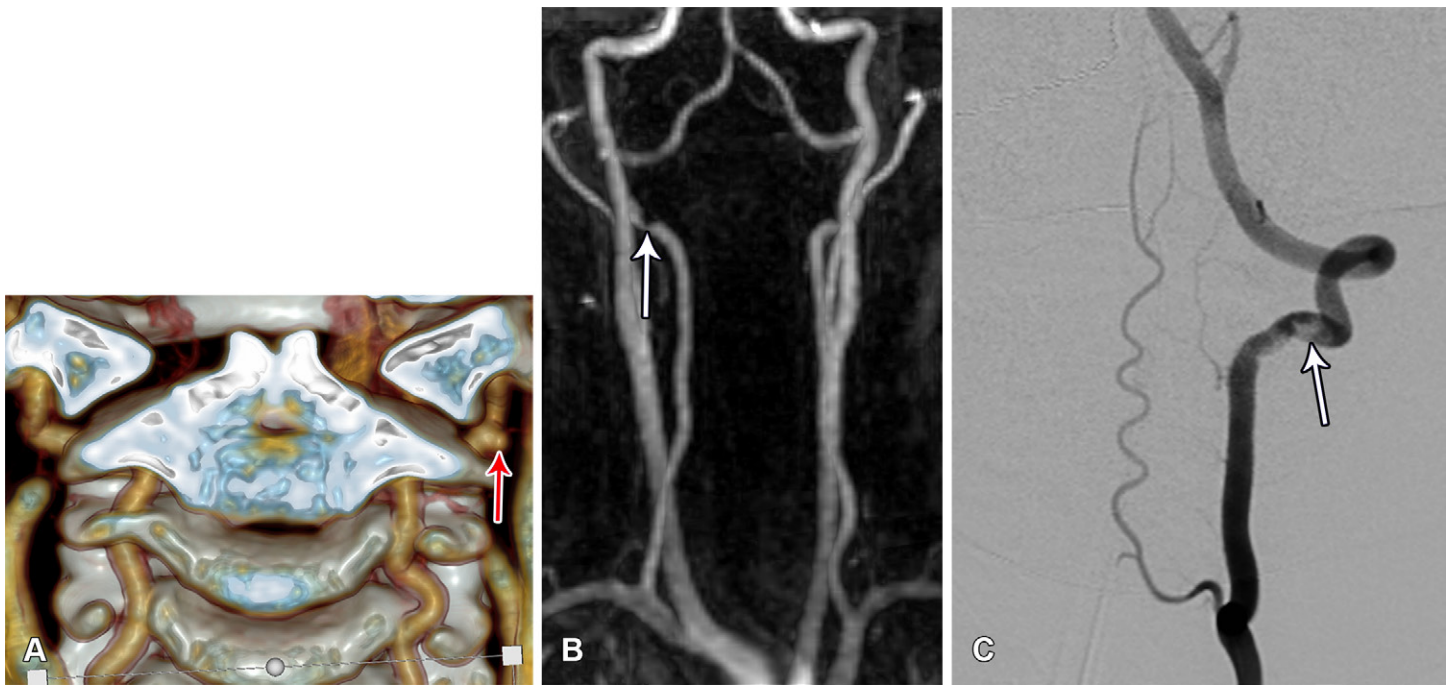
VAD in three children. Most VADs in children occur at the C2 level, particularly involving the V2-V3 segment junction or proximal horizontal V3 segment, possibly owing to repetitive microtrauma associated with the mobile lateral atlantoaxial joint. (A) Coronal volume-rendered CT angiogram in a 3-year-old boy shows a saccular pseudoaneurysm (arrow) at the V2-V3 junction. (B) Coronal 3D TOF MR angiogram in a 7-year-old boy shows eccentric mural thrombus (arrow) at the right V2-V3 junction. (C) Anteroposterior digital subtraction angiogram in a 21-month-old girl shows a filling defect (arrow) within the proximal V3 segment, consistent with VAD.
